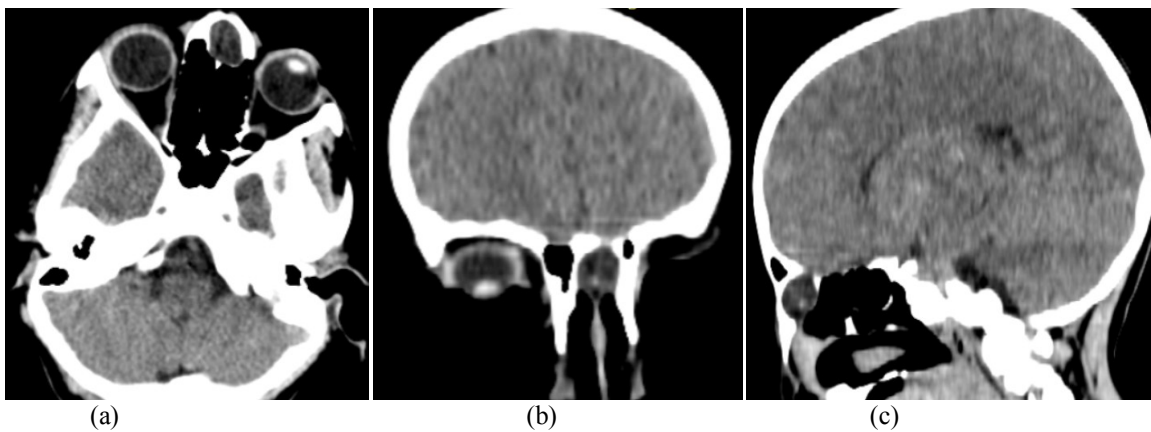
CT soft tissue window images (a. axial, b. coronal and c. sagittal) showing well defined lesion in frontonasal region with CT attenuation upto 15 HU. However definite intracranial extension can't be established on CT.
